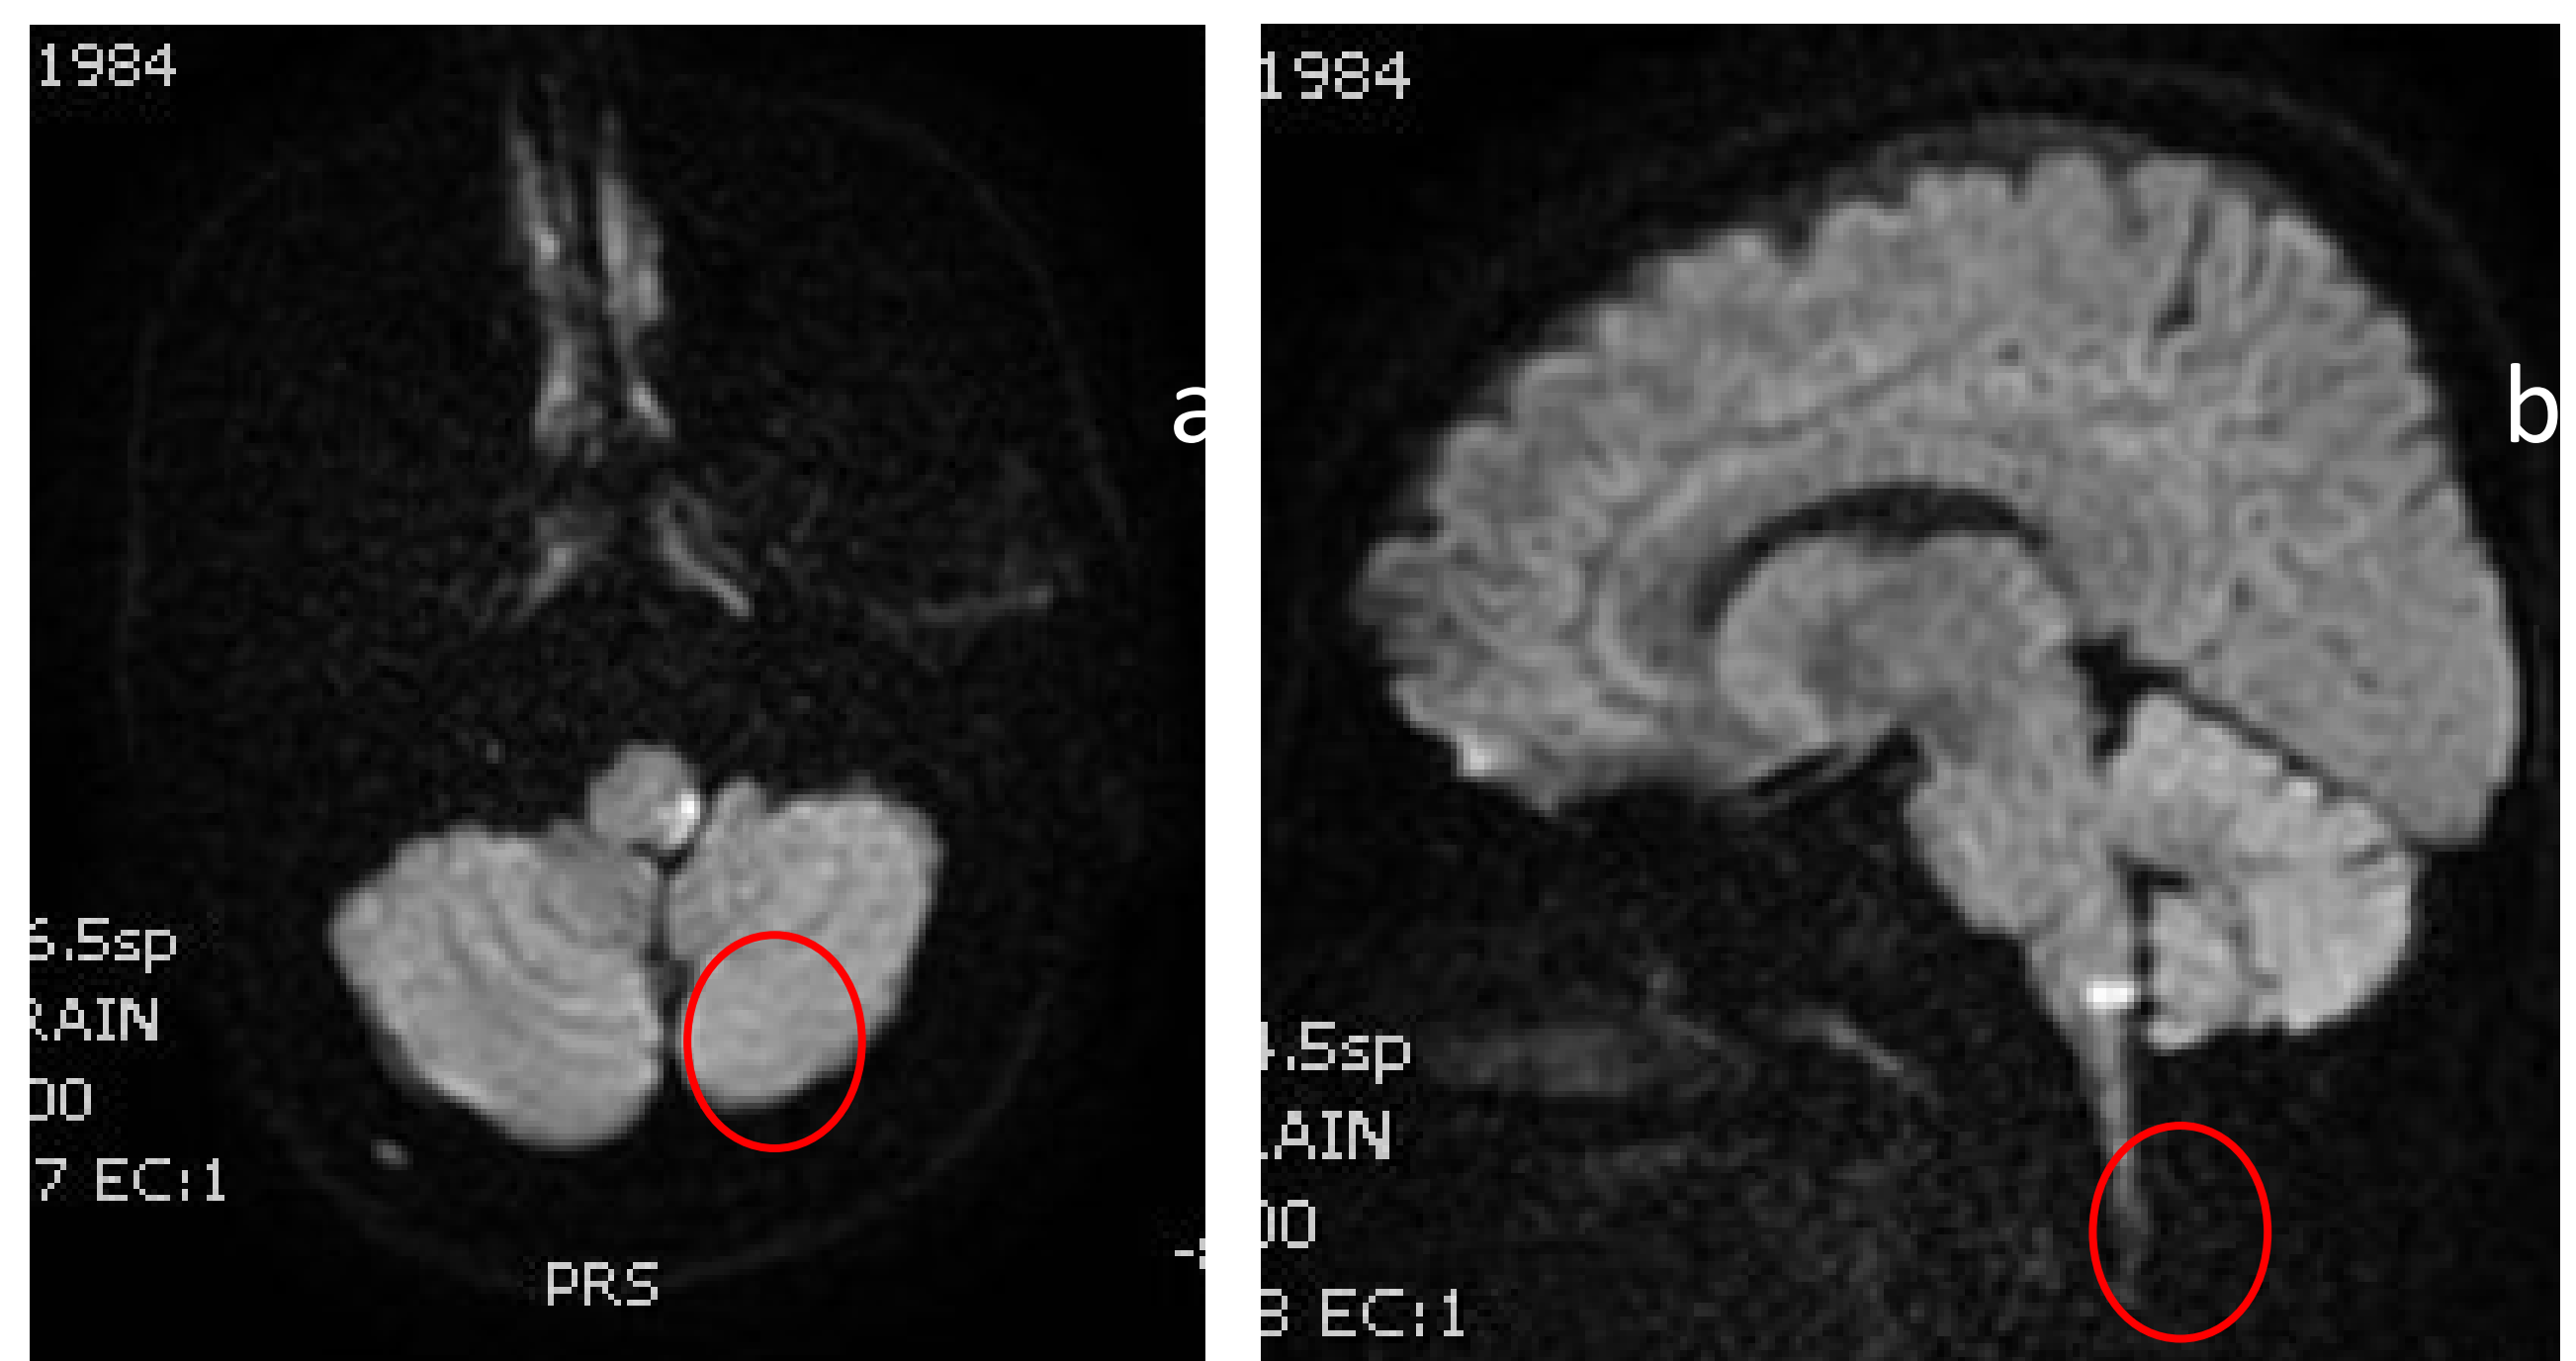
DWI brain MRI imaging: trasverse (a) and sagittal scans (b)
